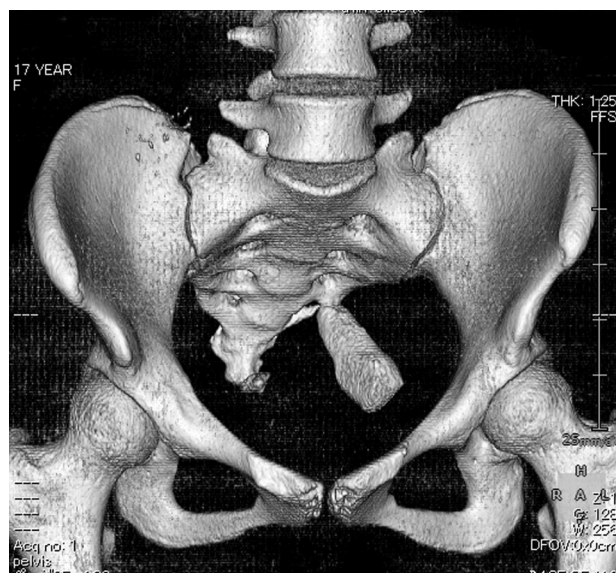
Three-dimensional computed tomography of the pelvis. The sacral rib is attached to the sacrum on the left side with a small articulation, and the inferior half of the sacrum is hypoplastic and deviated to the right side. (Top) Anterior view; (Bottom) posterior view.
